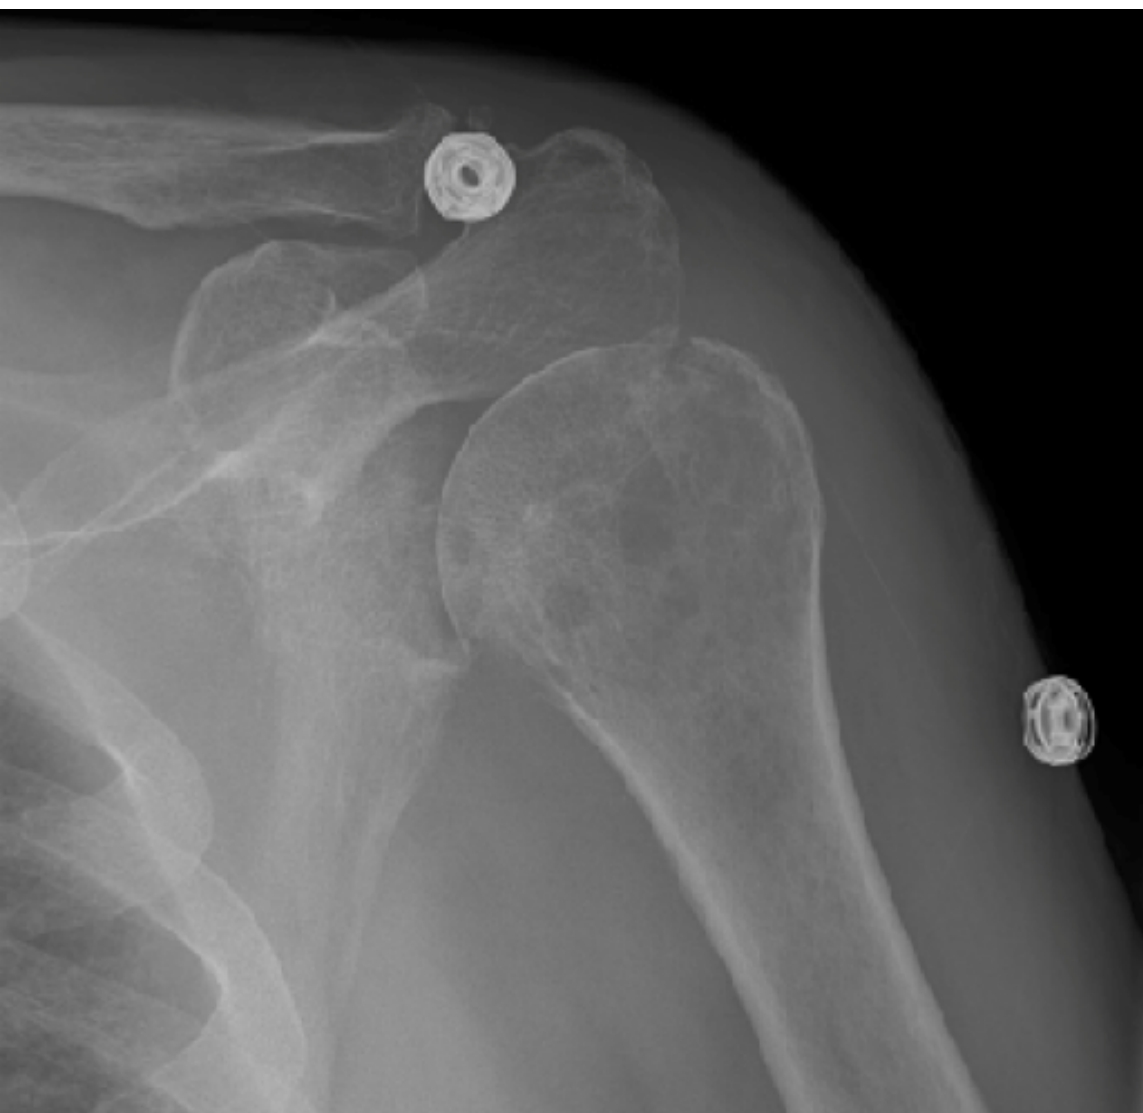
X-ray of left shoulder showing cortical irregularity of the greater tuberosity with probable lytic lesions in the humeral head concern for pathologic fracture.
